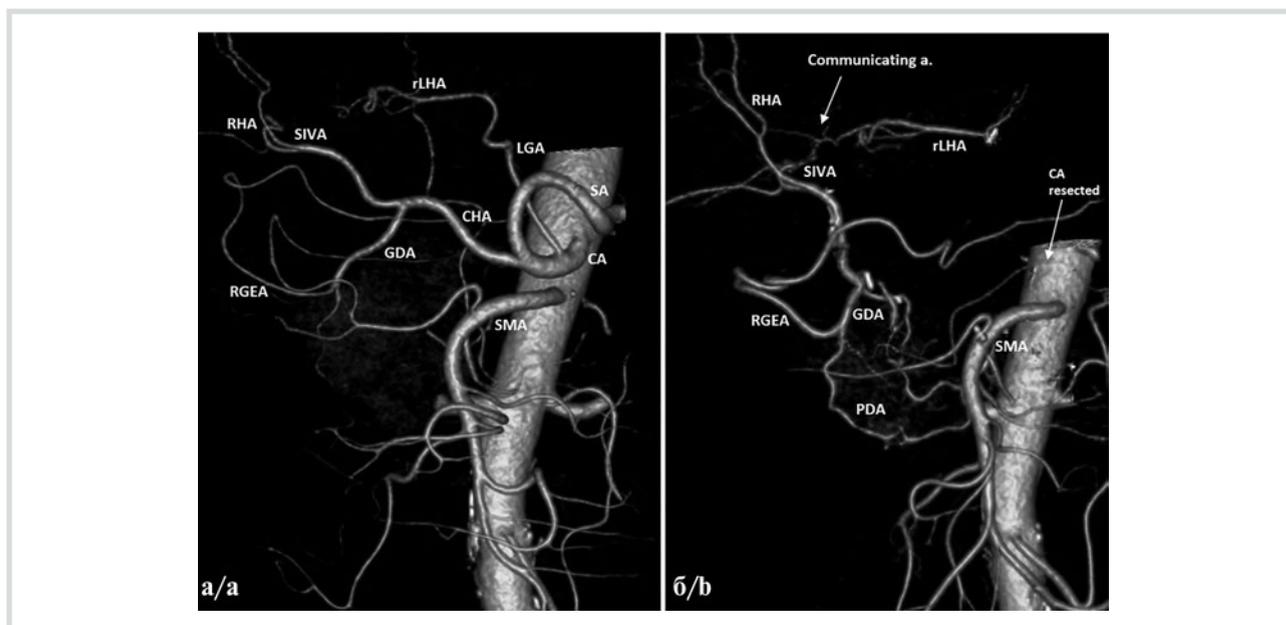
Ductal adenocarcinoma of the pancreatic body in a 62-year-old female. 3D CT angiography.
